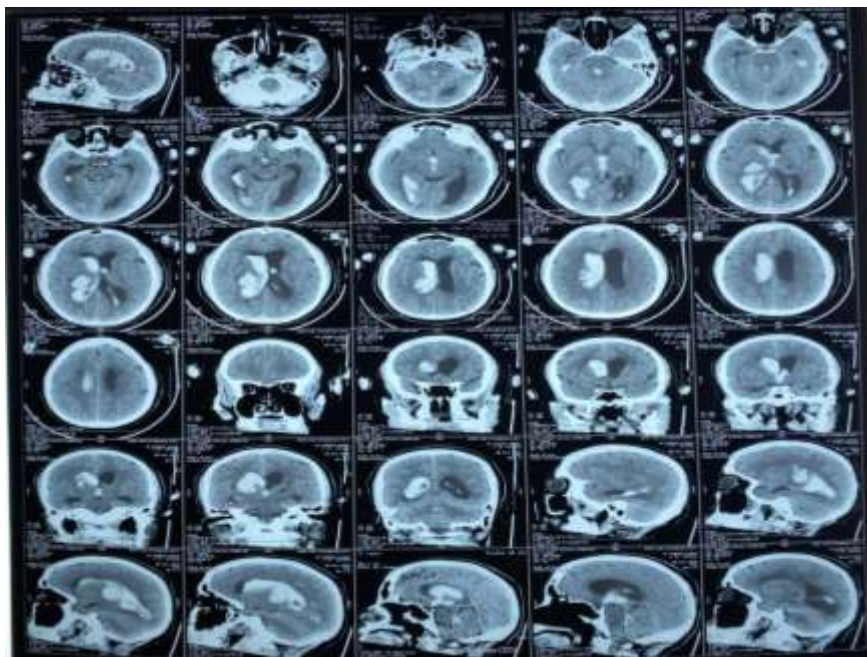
CT scan of the head without contrast. There are hyperdense lesions in the thalamus and intraventricular and non-communicating hydrocephalus.
